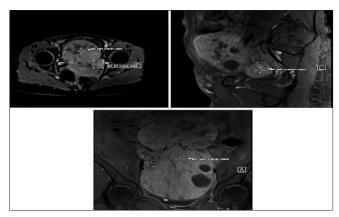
Contrast magnetic resonance imaging of pelvis showing large heterogeneously enhancing predominantly solid lesion in pelvis extending to the abdomen with a smaller lesion in left adnexa
